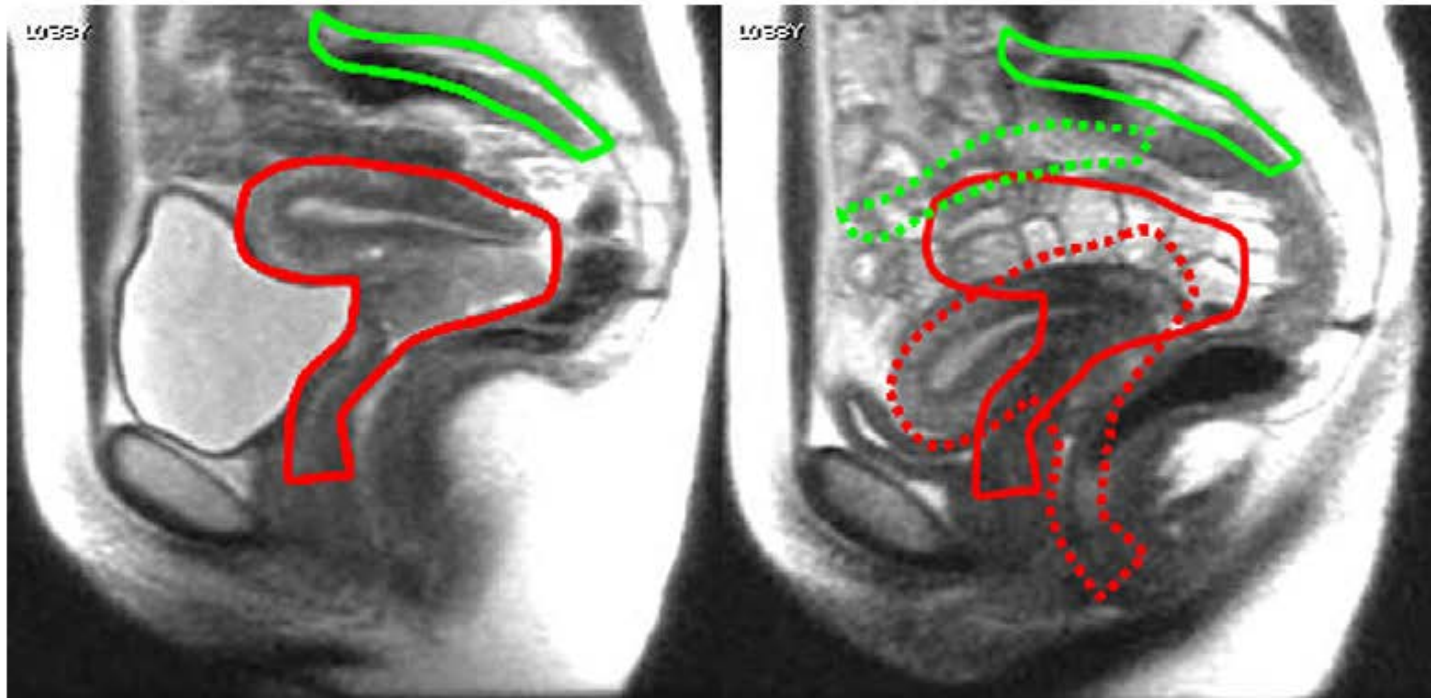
Sagittal T<sub>2</sub>-weighted MR images obtained 1 week apart from the same patient, demonstrating the marked difference between uterus and cervix positions, with altered bladder filling. Primary tumor CTV (red contour) and nodal CTV (green) contours overlaid. Solid lines represent targets at week 1, dashed lines represent the targets at week 2 if a direct translational shift is made to compensate for the change in the primary tumor CTV position. Nodal CTV and portions of tumor CTV in week 2 are missed.
